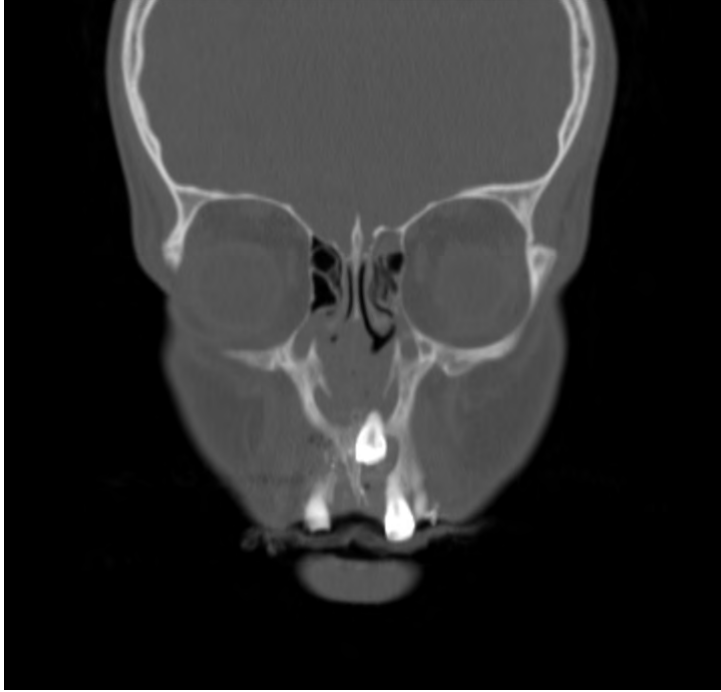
Post-traumatic CBCT image
